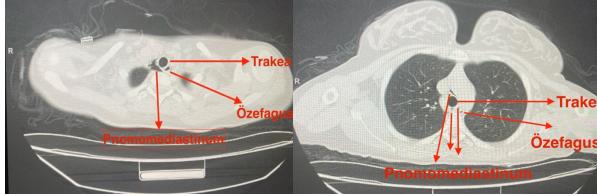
Pnomomediastinum appearance on thorax CT
